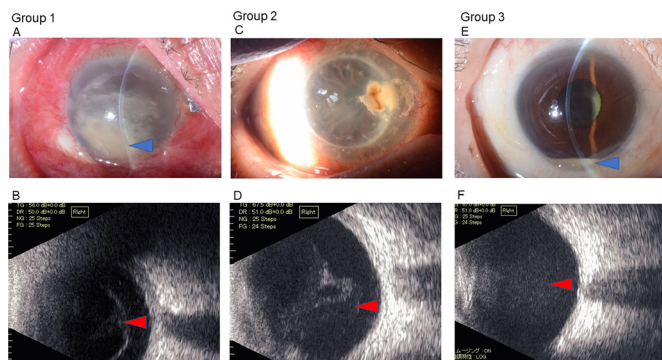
Representative clinical features from the three groups of patients. In all cases, severe inflammation such as hyperaemia and hypopyon (blue arrowheads) at the anterior segment and dense vitreous opacity (red arrowheads) in the vitreous body on B-scan ultrasonography were present. (A, B) Group 1: Cases with positive results for bacterial culture and metagenomic analysis. (C, D) Group 2: Cases with positive results for metagenomic analysis and negative results from bacterial culture. (E, F) Group 3: Cases with negative results for both methods of diagnosis.
